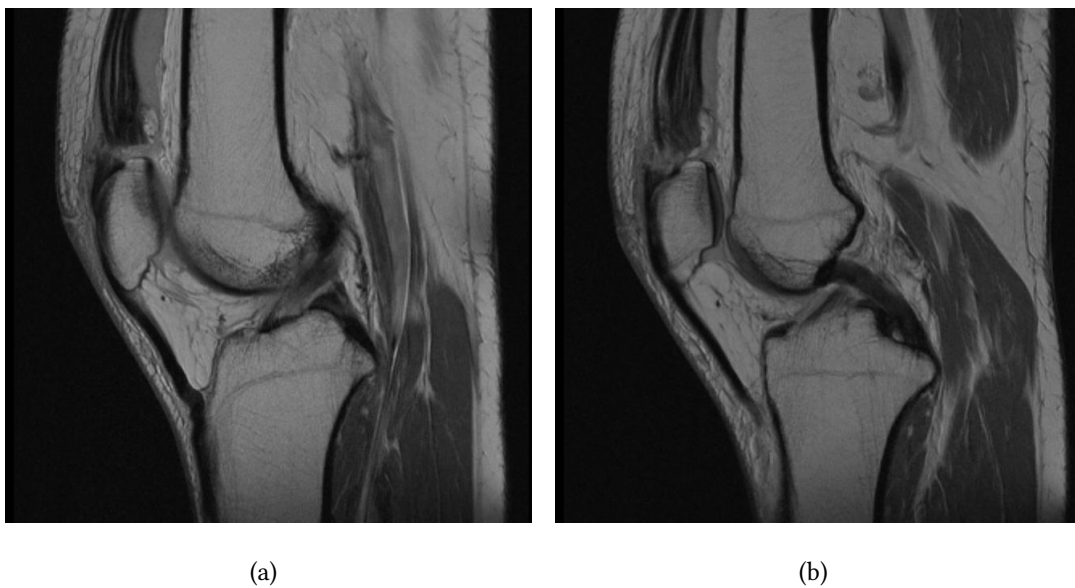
Quadriceps tendon tear on a sagittal view. The rupture can be seen as the black line discontinuity on the upper left-hand side of the image. PD MRI. Source: Case courtesy of Dr.Ajay C Desai, Radiopaedia.org, rID: 10826 [21]
